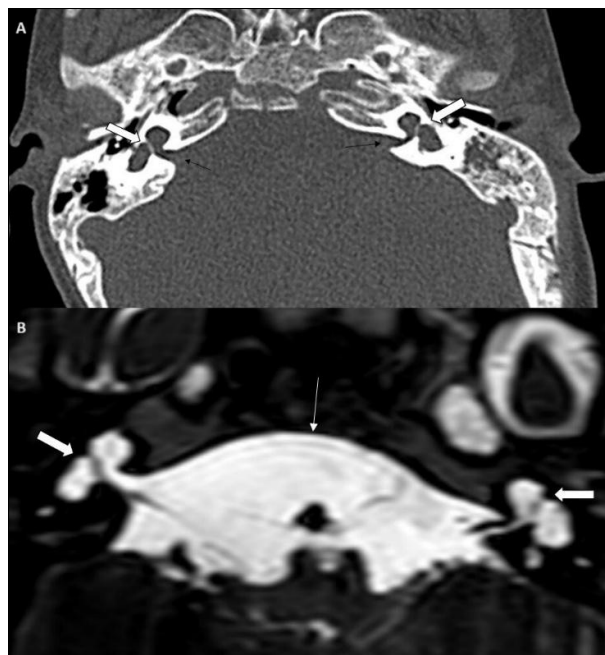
Image A is an axial computed tomography image of the temporal bone, and image B is an axial section of a highly T2-weighted (3D drive) sequence showing bilateral cystic dilatation of the cochlea and vestibule (marked by white block arrow) with absent turns of the cochlea and modiolus. A bilateral short internal auditory canal with a wide cochlear aperture is seen (marked by a black line arrow). Image B also shows the same findings with a widened prepontine cistern (marked by a white line arrow)
